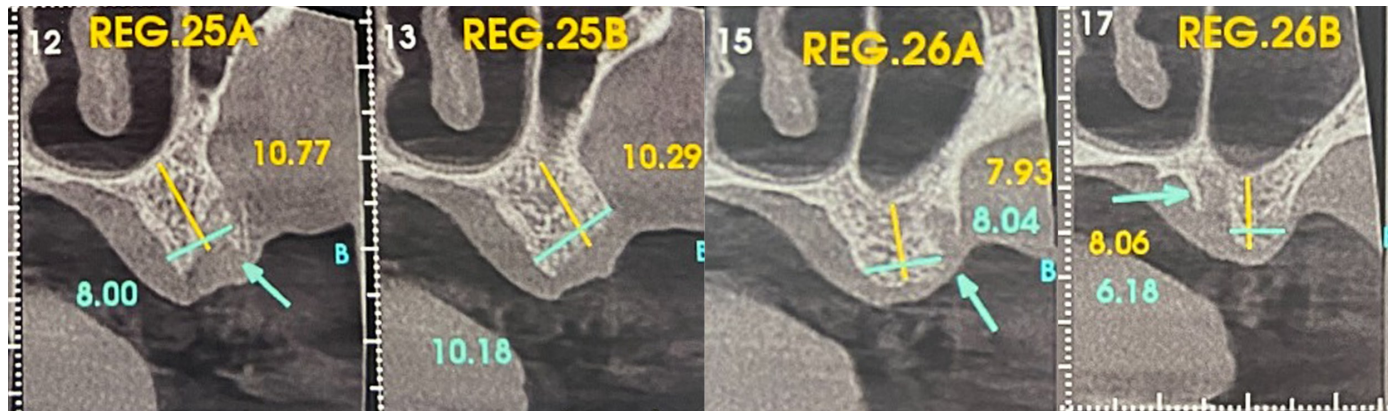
Computed tomography showing the maintenance and preservation of the ridge (after 2 months).
